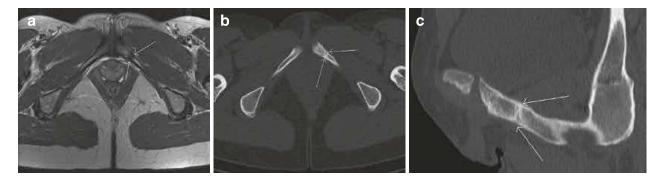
Inferior pubic ramus stress fracture (white arrows) on MRI (a) and CT views (b, c)
